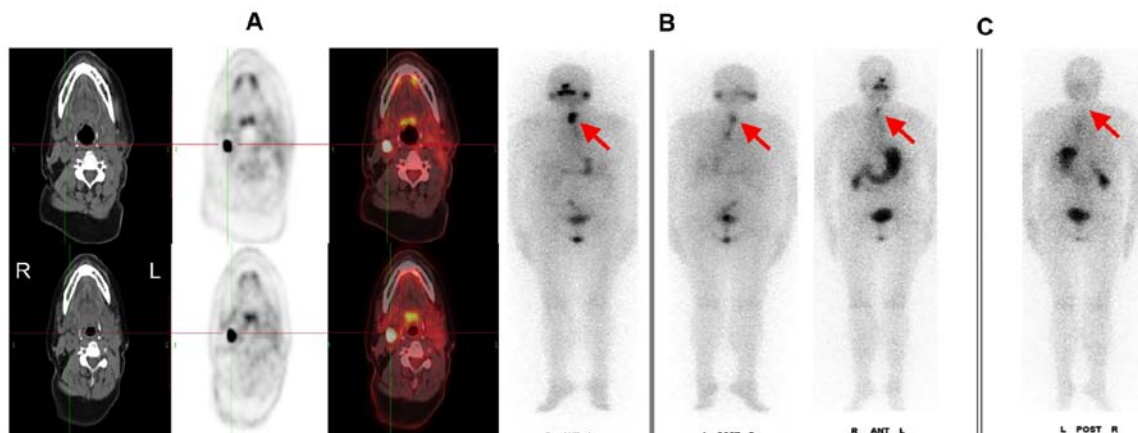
A 56-year-old female patient with papillary thyroid carcinoma with a mLN. CT revealed a LN with spherical shape and microcalcification in the right side of the neck. (A) The SULs of the LN (upper image) prior to and (lower image) following therapy were 47.2 and 47.6, respectively (the cross point). (B) First ^{131}I whole-body scan image revealed high ^{131}I accumulations in the cervix (red arrow). (C) Uptake of ^{131}I reduced following the second therapy, however the SUL was markedly higher (the red arrow). The lesion was defined as stable disease. SUL, standardized uptake value; mLN, metastatic lymph node; LN, lymph node; CT, computed tomography; ^{131}I , iodine-131.
